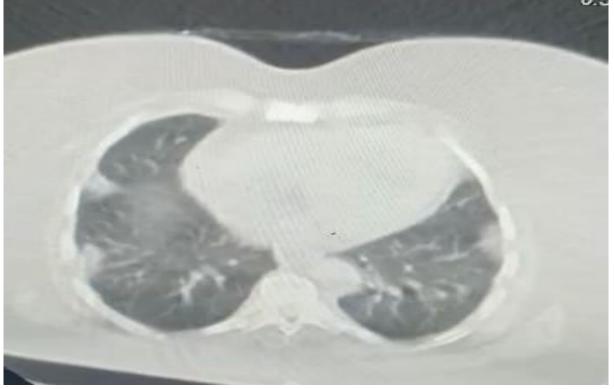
CT Chest of a female shows ground glass opacity
